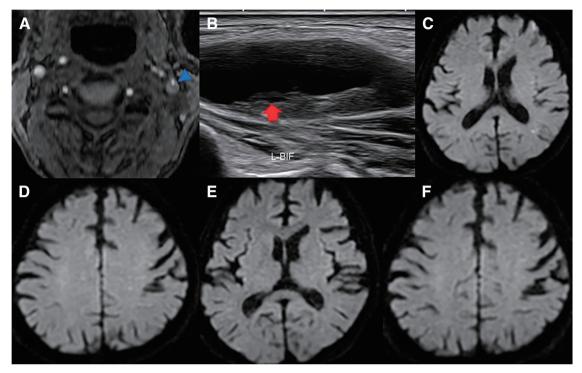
Preoperative plaque images and postoperative MRI. (A) Preoperative plaque image by TOF. The plaque shows high intensity compared to the sternocleidomastoid muscle (blue arrowhead). (B) Preoperative plaque image by carotid duplex. The plaque appears low overall, and a linear echo-free space is seen in the plaque (red arrow). (C and D) The DWI images after the first surgery. A few tiny high-intensity spots can be seen (asymptomatic). (E and F) The DWI images after the second procedure. There are no additional lesions. TOF: time-of-flight
